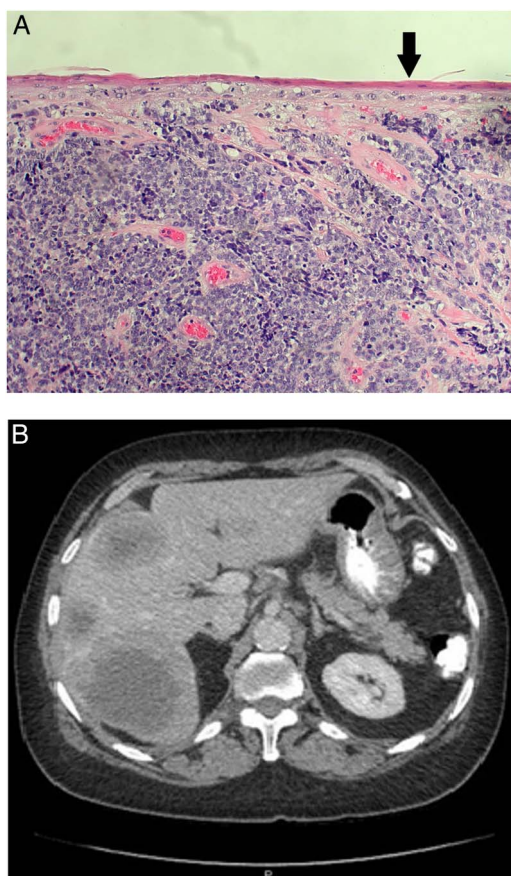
(A) High-grade neuroendocrine carcinoma invading beneath the anal squamous epithelium (arrow). (B) Axial CT abdomen showing multiple metastatic hepatic lesions.
